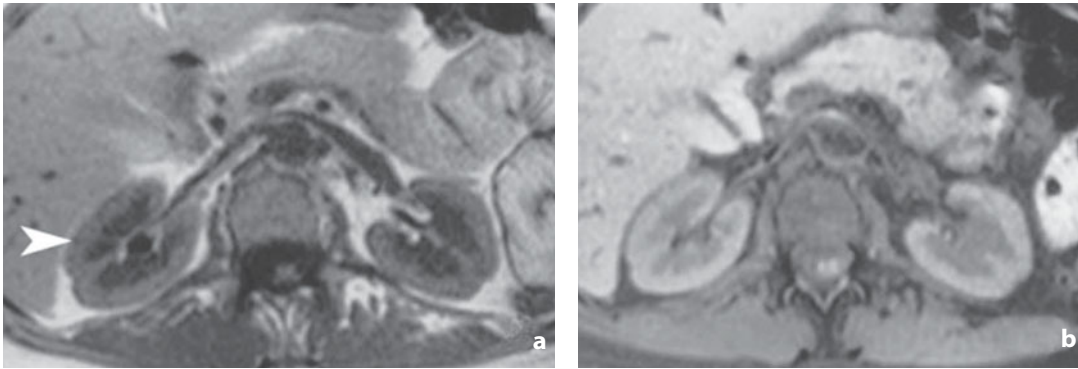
Magnetic resonance. Kidney. a Axial T1-weighted image. The renal cortex (*arrowhead*) displays higher signal intensity than the medulla. b Axial T1-weighted image with fat saturation. The cortex maintains higher signal intensity than the medulla. Note the suppression of the perirenal fat signal. c Axial T2-weighted image. The difference in T2 relaxation time enables differentiation between the cortex and medulla
